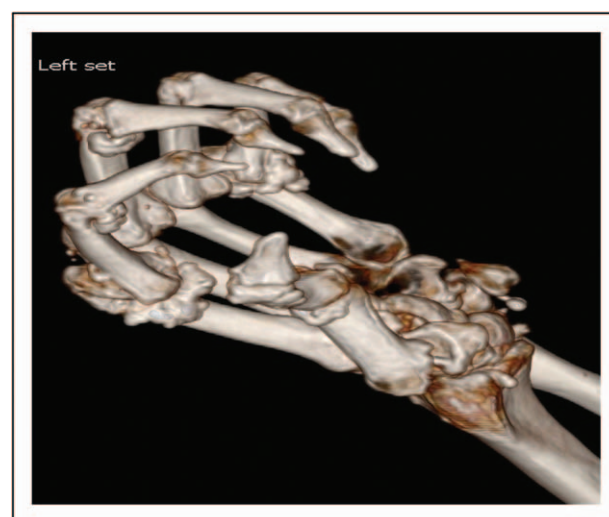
Calcinosis imaged by dual-energy computed tomography scan showing tumorous deposits attached to tendons and ligaments at the PIP, MCP and wrist joints. MCP, metacarpal phalangeal joint; PIP, proximal interphalangeal joint.
